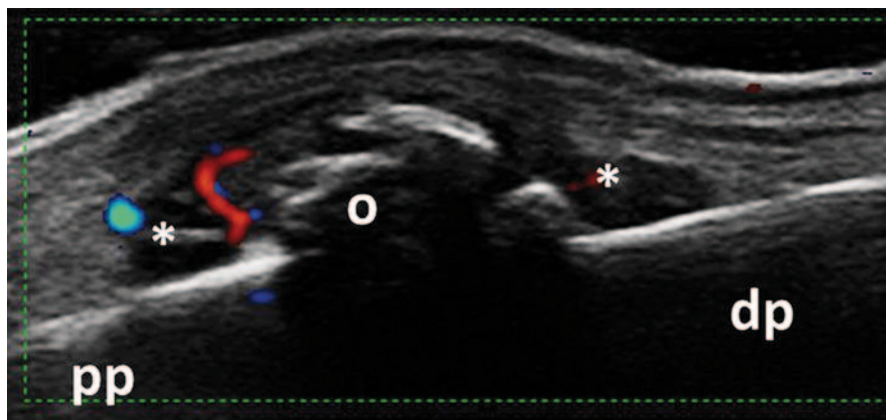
Longitudinal view of the dorsal aspect of the proximal interphalangeal joint showing B-mode synovitis (*asterisk*) with Doppler signal and osteophytes in a patient with osteoarthritis; *pp* proximal phalanx, *dp* distal phalanx, *o* osteophytes
